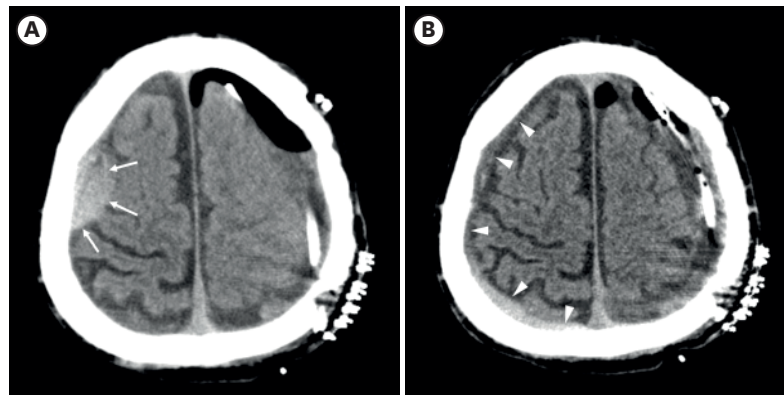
Brain CT scan after BHT. (A) CT scan taken immediately after BHT shows lentiform high density hematoma (arrows) in the right frontal region. (B) CT scan taken 12 hours later shows disappearance of lentiform hematoma and spread of the hematoma along the right cerebral hemisphere (arrow heads).
